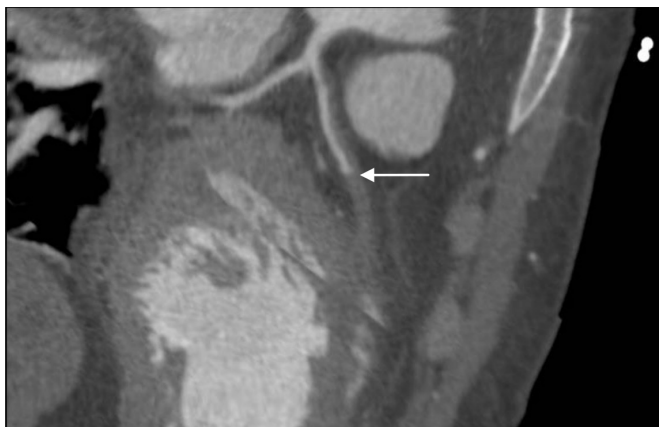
CT coronary angiogram demonstrating complete occlusion of the left anterior descending artery from the first septal branch (arrow).
